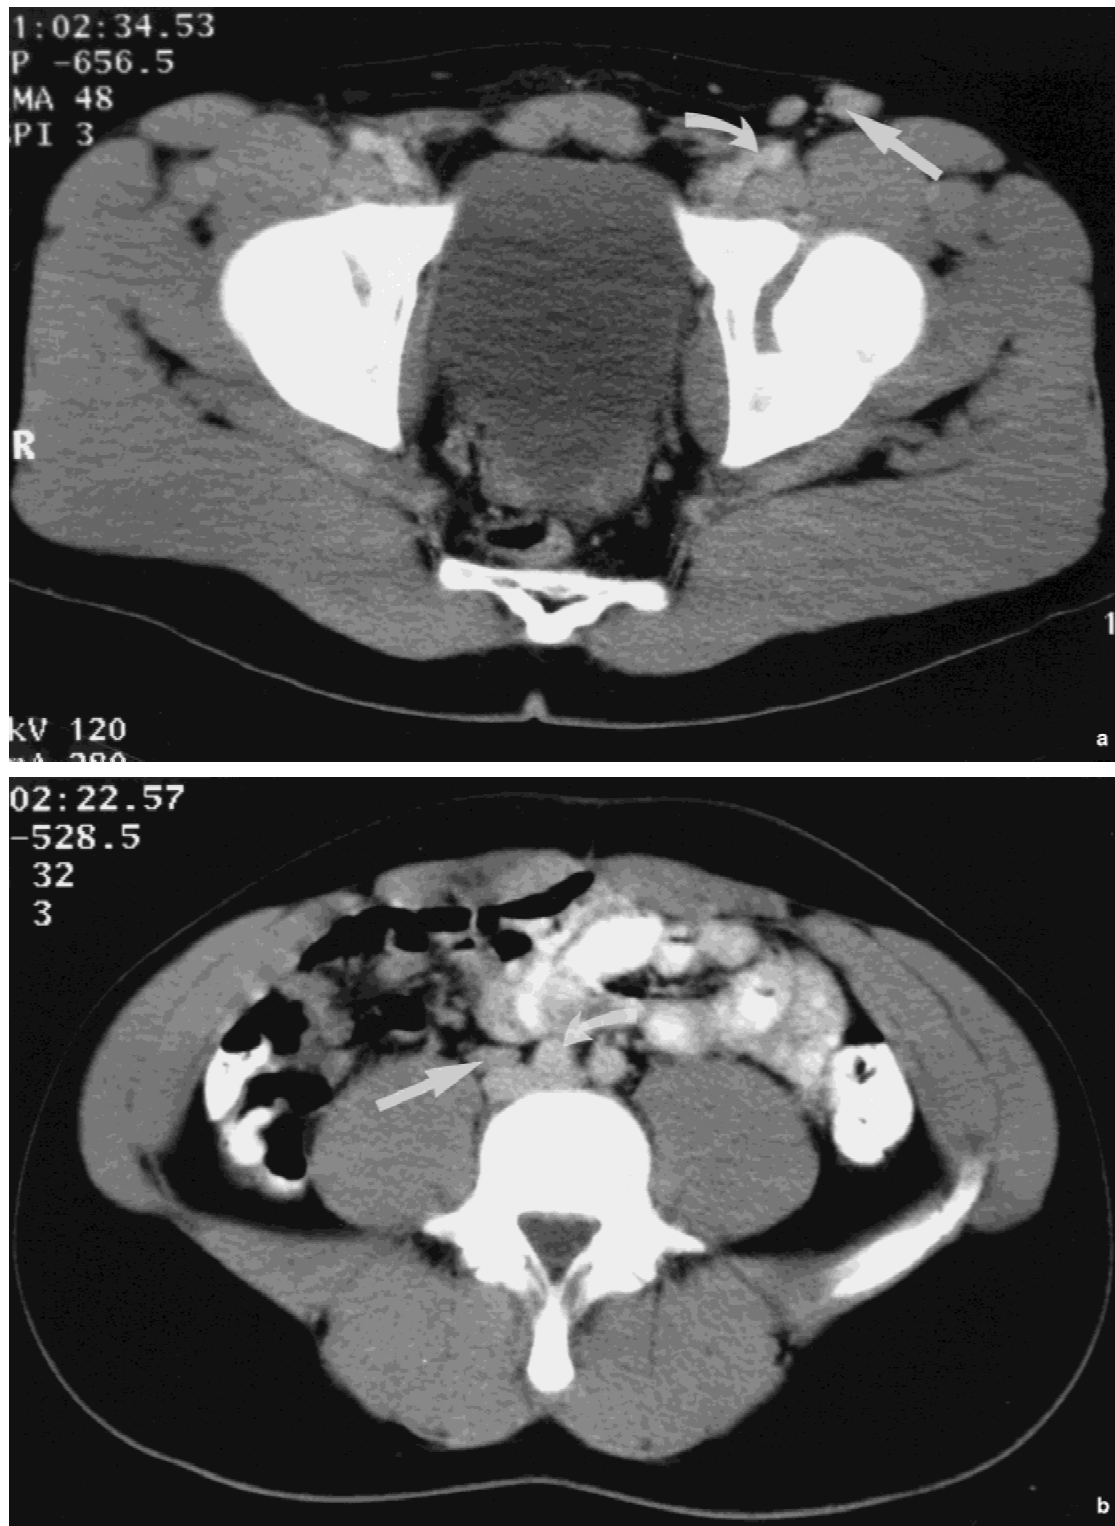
Contrast enhanced helical CT (8 mm slice thickness) after chemotherapy shows (a) marked reduction in the size of the enlarged lymph nodes in the left groin (straight arrow) anterior to the common femoral artery and vein (curved arrow) as well as (b) in the right iliac chain (straight arrow). Curved arrow indicates the bifurcation of the aorta and inferior vena cava.
